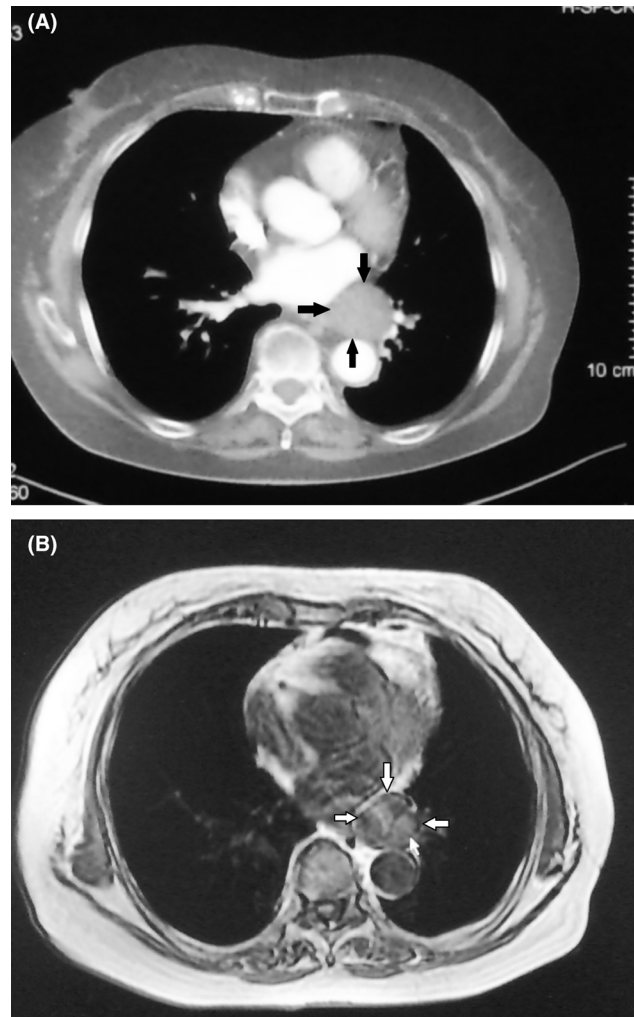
A well-circumscribed mass with smooth margin which located in the visceral mediastinal compartment (with black arrow) in the chest computed tomography scan (A) and with white arrow in the chest magnetic resonance images (B)
